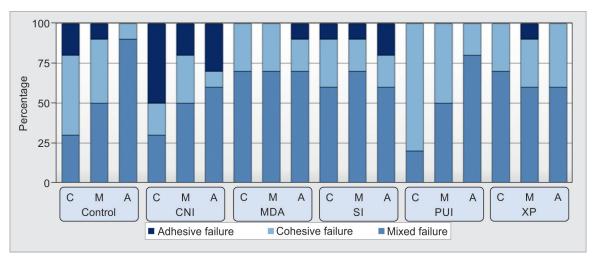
Stacked bar chart showing the percentage distribution of failure mode of all experimental groups obtained from different levels of the root canal (C, coronal; M, middle; A, apical; CNI, conventional needle irrigation; MDA, manual dynamic agitation; SI, sonic irrigation; PUI, passive ultrasonic irrigation; XP, XP-endo Finisher)
